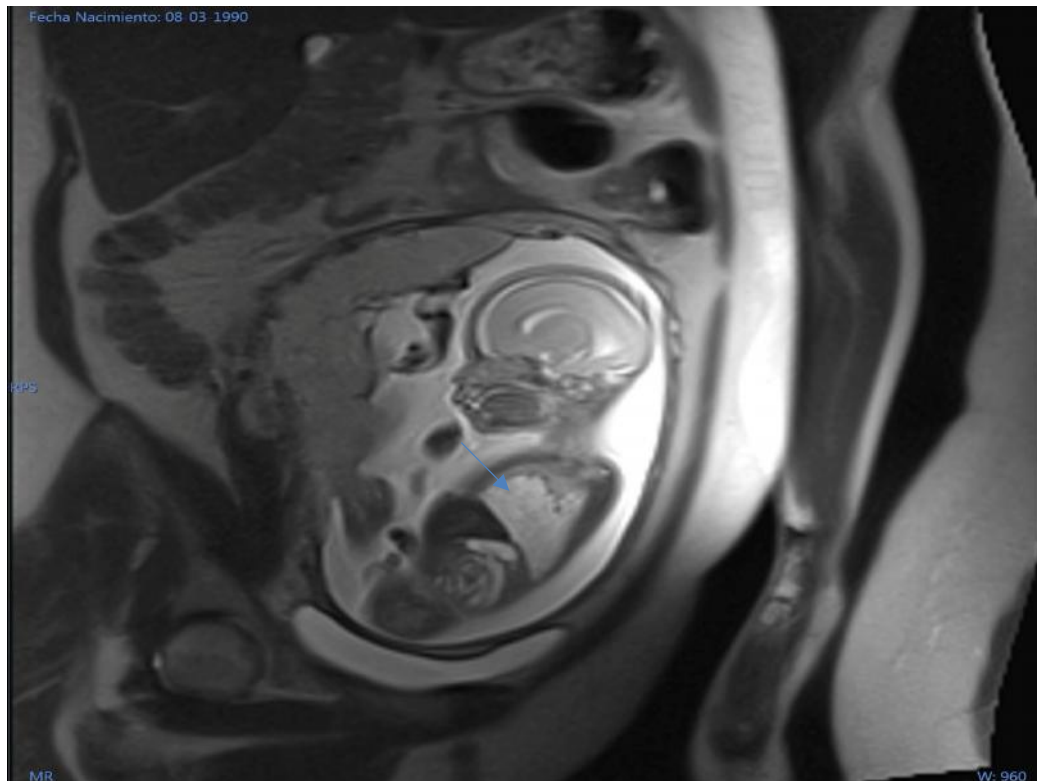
T2-weighted MRI, sagittal plane: It is identified irregular hyperintense image essence of the right lung (arrow), without defining the cystic component.
